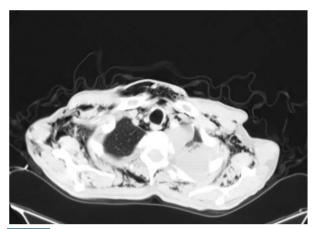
Axial CT image at the level of the thoracic inlet demonstrated extensive subcutaneous emphysema, particularly prominent in the bilateral supraclavicular and anterior chest wall regions, along with pneumomediastinum evidenced by air outlining mediastinal structures
